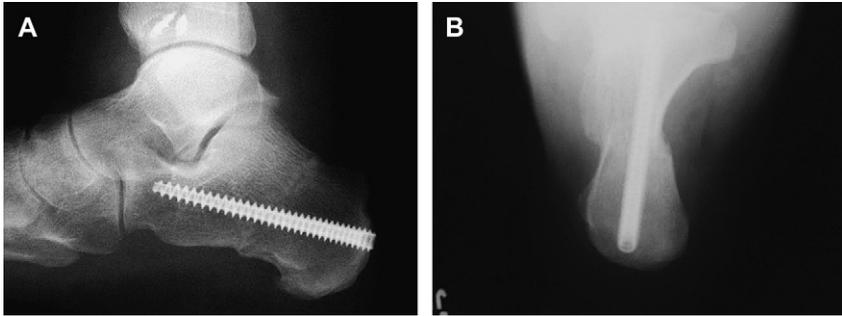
(A, B) Lateral and calcaneal radiographs of an MCO.
